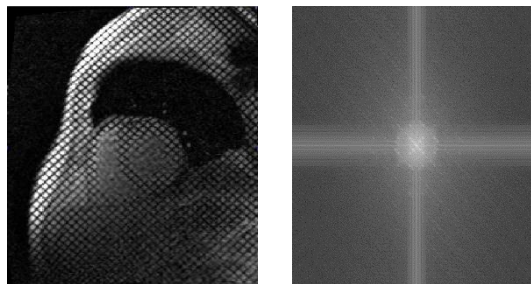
Example of a cardiac MR image (left) and the corresponding k-space (right).
